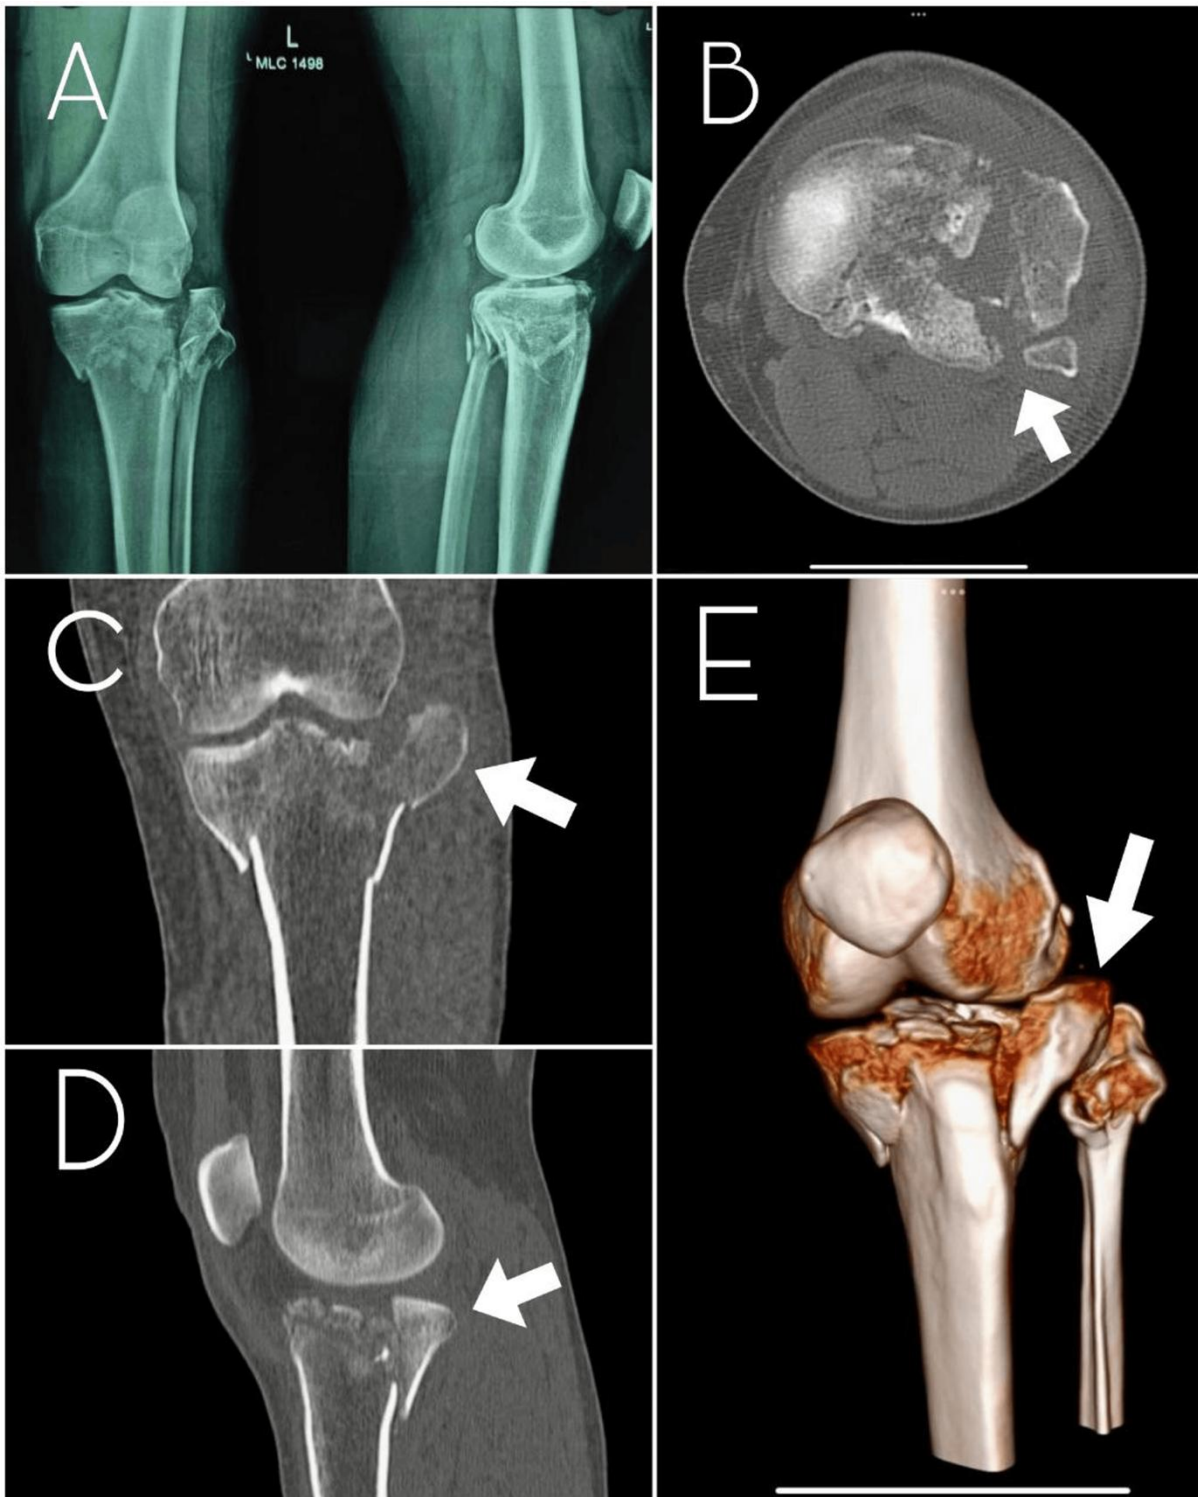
Case-2: pre-operative radiograph and CT views of a 36 year old male patient diagnosed with proximal tibia fracture schatzker type 5.
